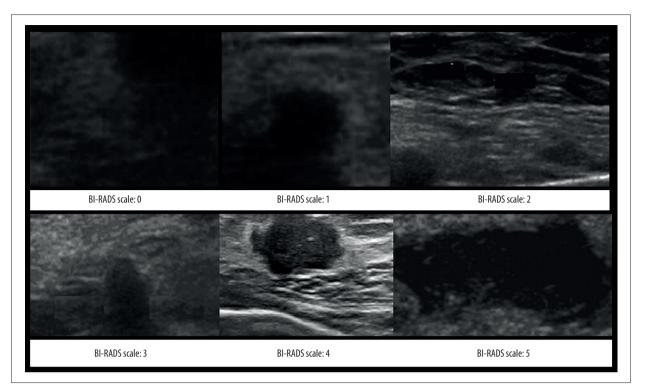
The Breast Imaging-Reporting and Data System (BI-RADS) scores according to the breast ultrasound.
